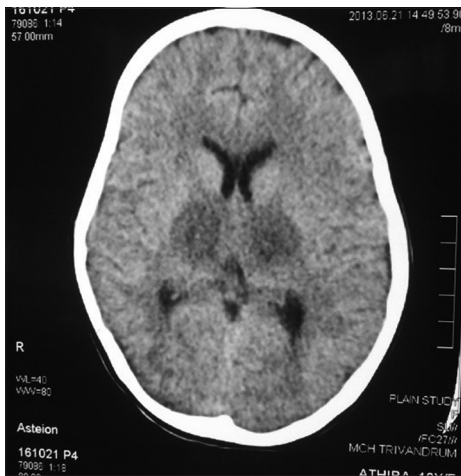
CT scan head showing bilateral thalamic hypodensity in a child with dengue encephalitis
